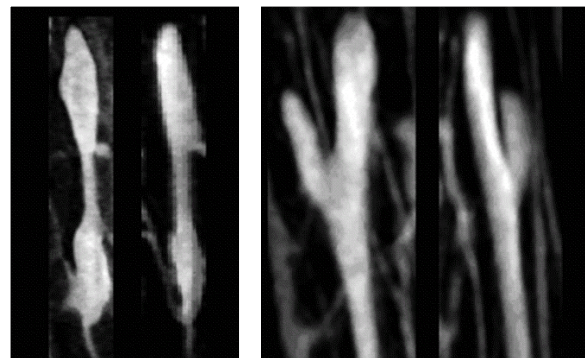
Micro-computed tomography images of bidirectional (left) and branched (right) BMU morphologies (Cooper et al., 2006).
